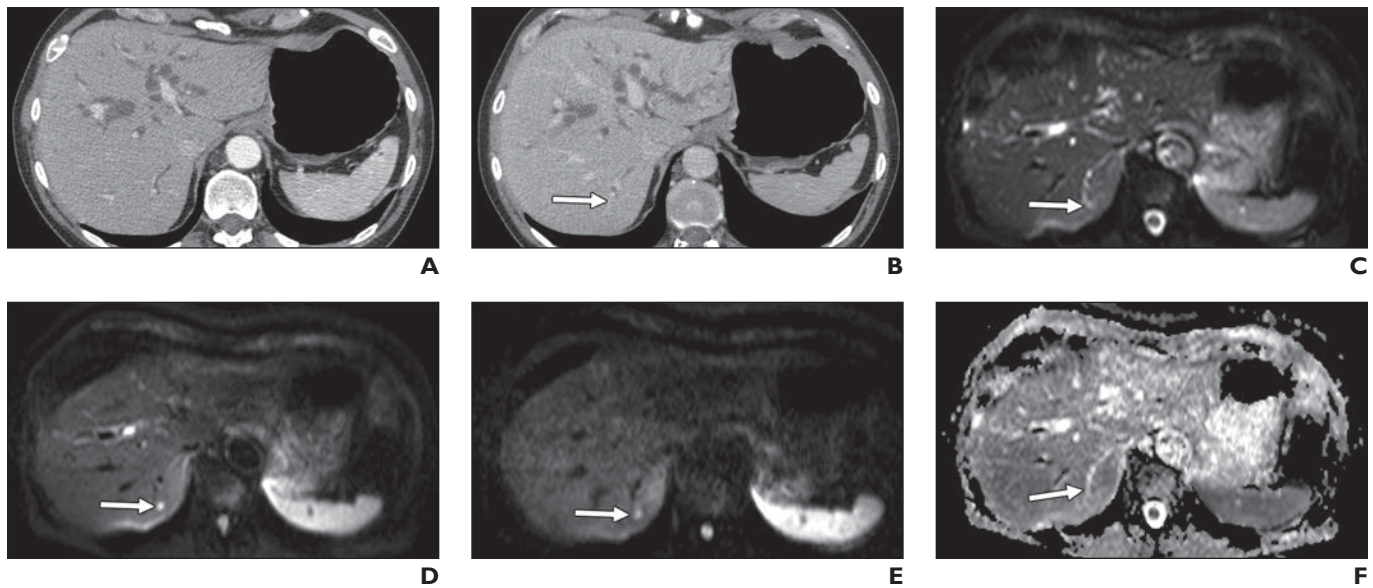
56-year-old man with potentially resectable pancreatic adenocarcinoma undergoing preoperative imaging consisting of CT followed by MRI. Lesion was biopsied during surgery.
